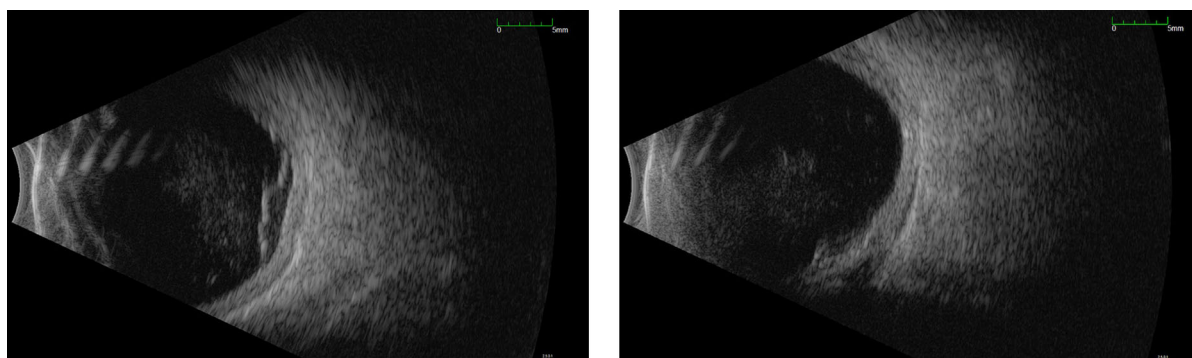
Images of B-scan ultrasonography of the right eye of our patient. The image on the left demonstrates vitreous debris and subretinal fluid, concerning for RD in the setting of vitreous pigment, myopia, and chronic rubbing
